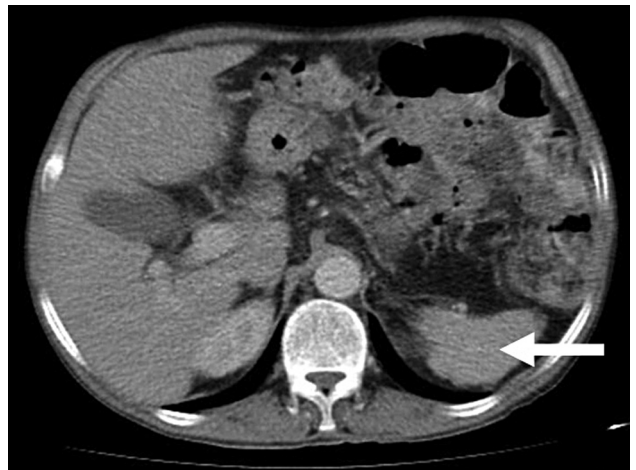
Abdominal CT shows cirrhotic liver and splenic atrophy (arrow) after adherence to a strict gluten-free diet for one year.
